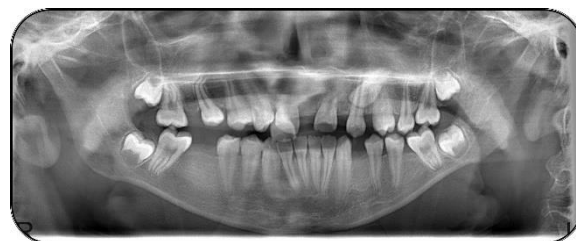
Radiographic appearance after the extraction of supernumerary teeth.
